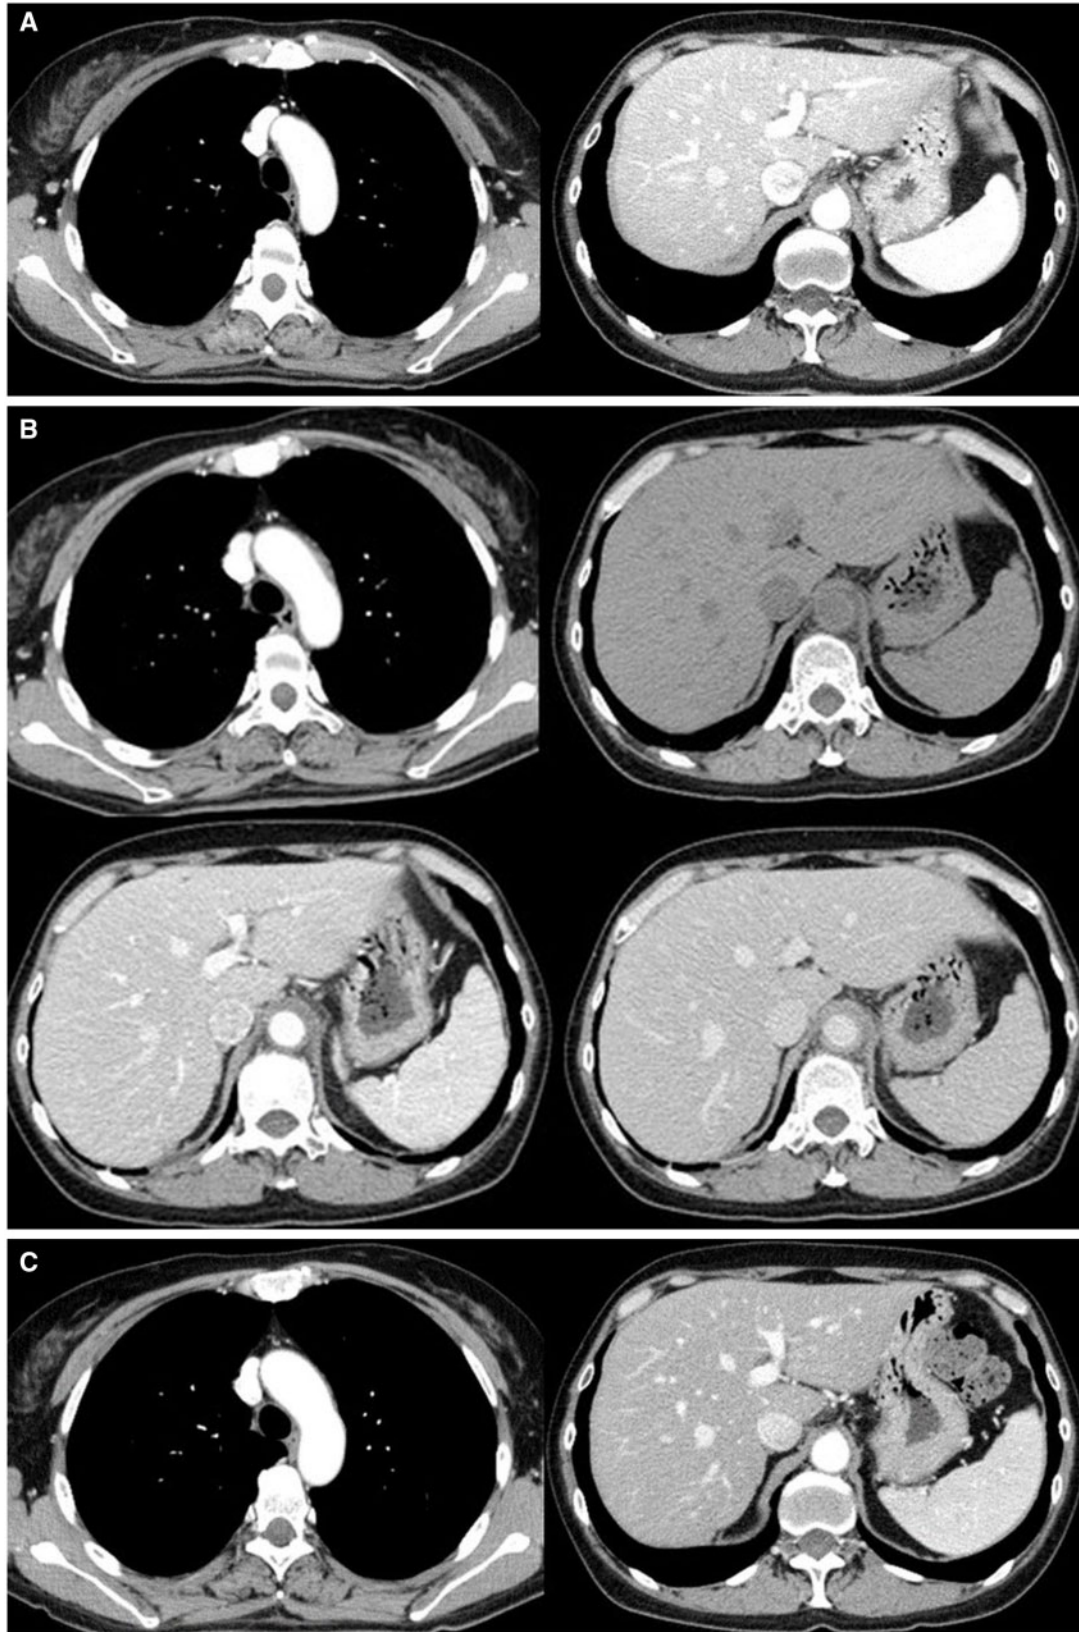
Imaging findings via enhanced computed tomography. (A) Enhanced computed tomography (CT) findings before chemotherapy. (B) The computed tomography findings after onset (chest: early phase, abdomen: plain, early, and delay phase), which revealed enhancement of the peri-aortic tissue from the aortic arch and the abdominal aorta (vs. the pre-chemotherapy findings). There was no wall thickening in the branches of the aorta, aortic stenosis, aneurism, or dissection. (C) Enhanced computed tomography after the treatment for aortitis. The thickening around the aorta had improved after 2 weeks.
